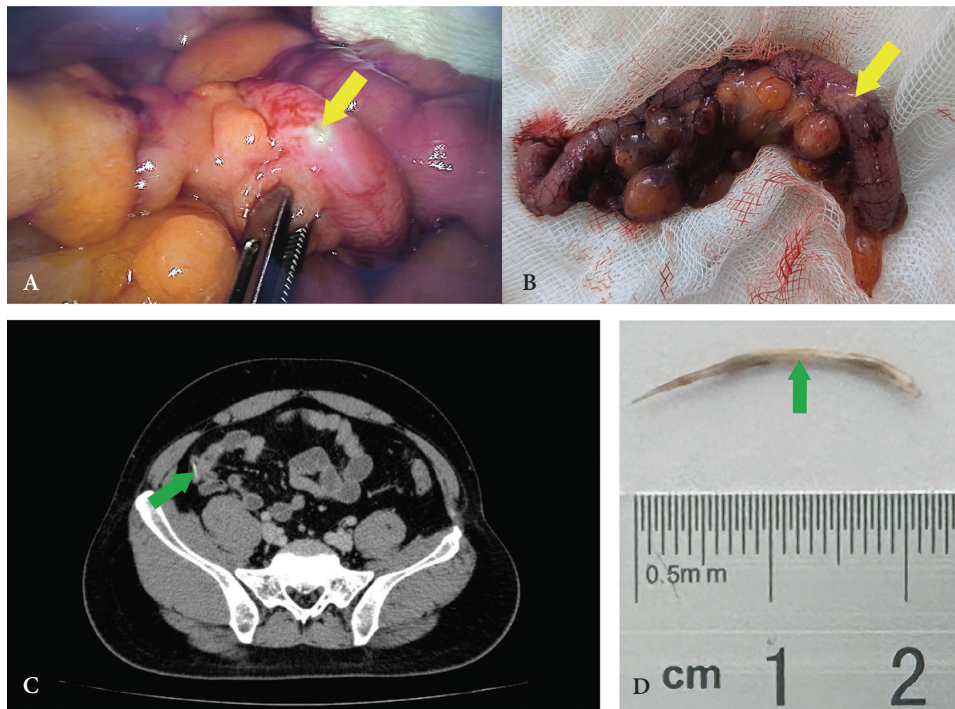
(A) Laparoscopic intraoperative view in Case 3, a 32-year-old male patient, showing perforation near the appendiceal tip (yellow arrow) with surrounding fibrinous exudate. (B) Gross appearance of the resected appendix following appendectomy. (C) Preoperative contrast-enhanced computed tomography demonstrating a linear, slender foreign body (green arrow) penetrating the appendiceal wall. (D) The retrieved fish bone (green arrow) after longitudinal incision of the appendix, measuring approximately 20 mm in length
